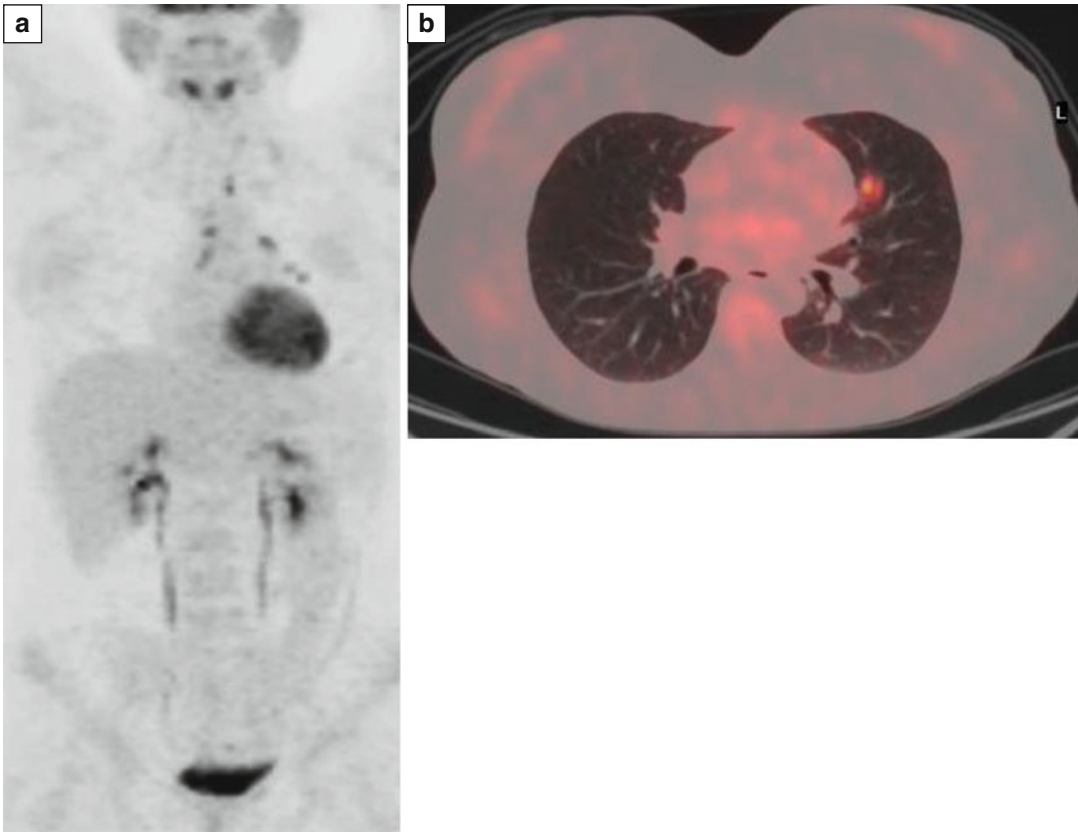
(a, b) MIP-PET and fused PET/CT – after immunochemotherapy with R-CHOP: Small, high hypermetabolic mediastinal lymph nodes (D5-PS score 5) (a) and hypermetabolic nodule at the left upper lung lobe (b)
